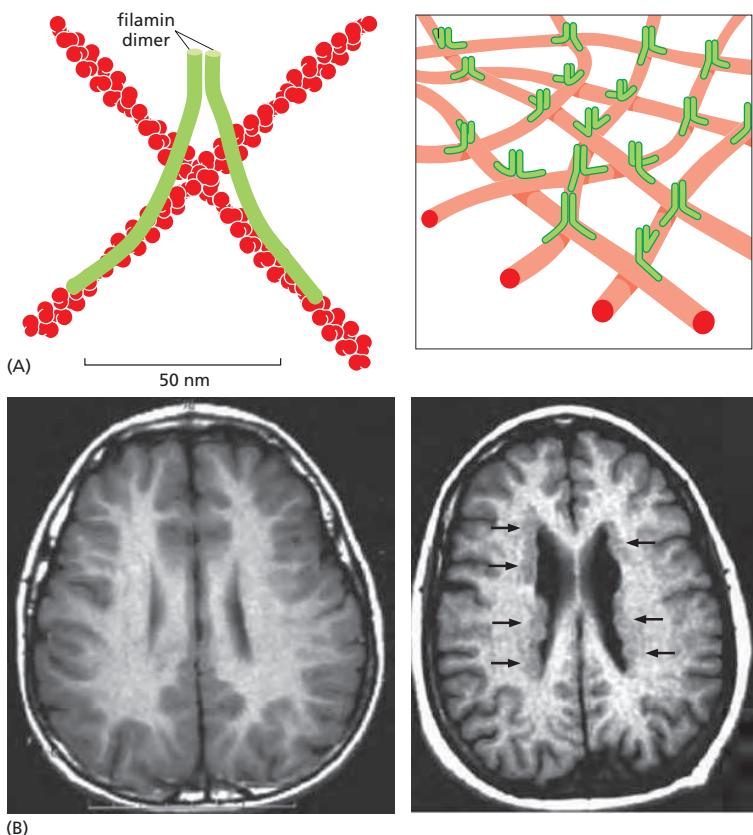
Filamin cross-links actin filaments into a three-dimensional network and is required for normal neuronal migration. (A) Each filamin homodimer is about 160 nm long when fully extended and forms a flexible, high-angle link between two adjacent actin filaments. A set of actin filaments cross-linked by filamin forms a mechanically strong web or gel. (B) Magnetic resonance imaging of a normal human brain (left) and of a patient with periventricular heterotopia (right) caused by mutation in the filamin A gene. In contrast to the smooth ventricular surface in the normal brain, a rough zone of cortical neurons (arrowheads) is seen along the lateral walls of the ventricles, representing neurons that have failed to migrate to the cortex during brain development. Remarkably, although many neurons are not in the right place, the intelligence of affected individuals is frequently normal or only mildly compromised, and the major clinical syndrome is epilepsy that often starts in the second decade of life. (B, adapted from Y. Feng and C.A. Walsh, *Nat. Cell Biol.* 6:1034–1038, 2004. With permission from Macmillan Publishers Ltd.)
